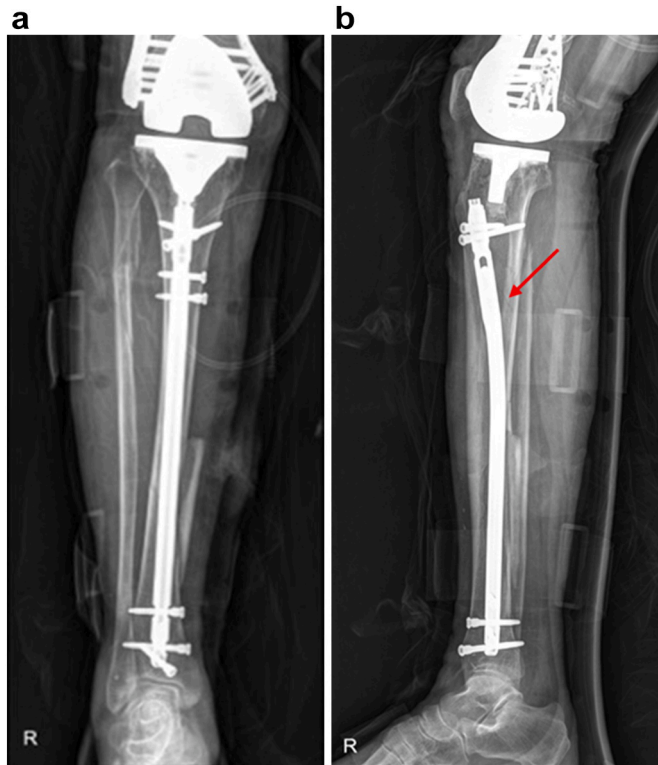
Immediate postoperative simple radiographs demonstrating crack of the proximal metaphysis (arrow). (A) Anteroposterior and (B) lateral images.
